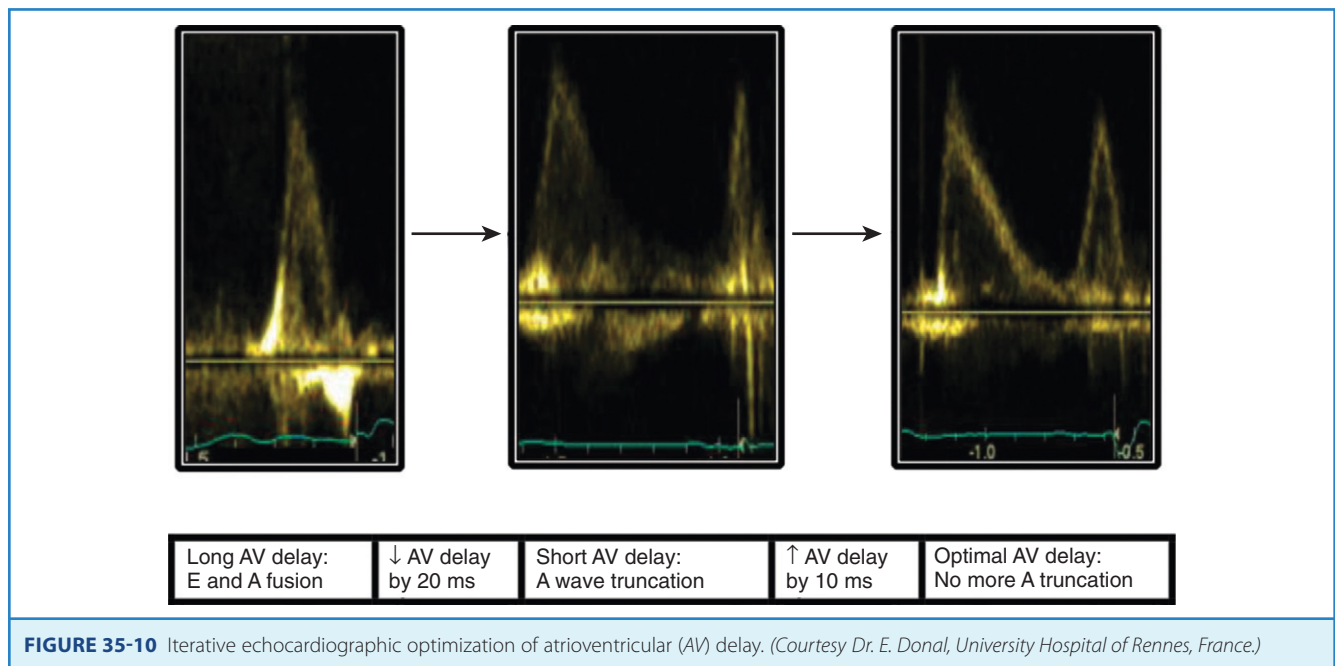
Iterative echocardiographic optimization of atrioventricular (AV) delay. (Courtesy Dr. E. Donal, University Hospital of Rennes, France.)
